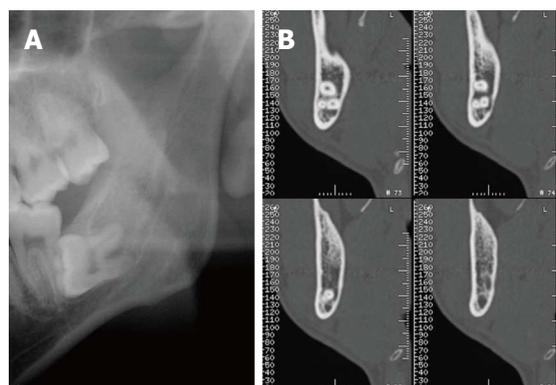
Radiolucency is not observed with orthopantomography. A: No significant radiolucency is observed in the roots of the third mandibular molar with orthopantomography; B: A cross-sectional multi-detector computed tomography image shows the dumbbell shape of the inferior alveolar canal and loss of the lingual cortex of the mandibular bone.
